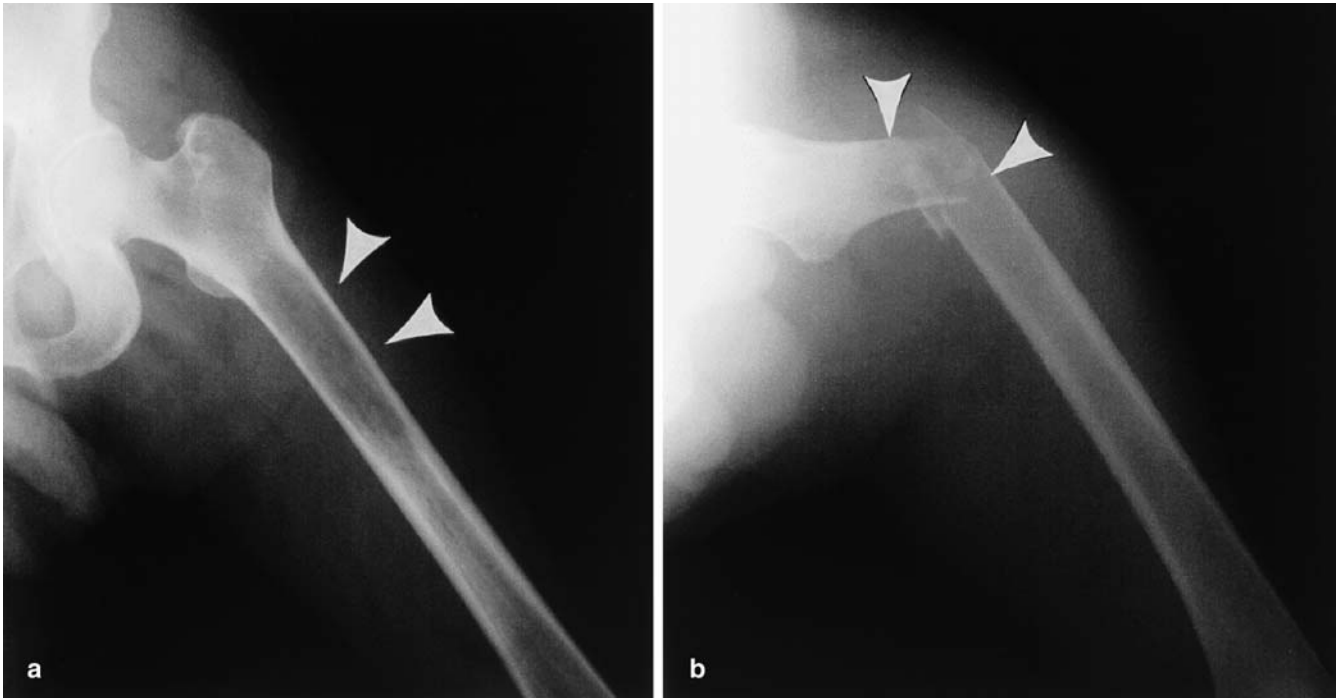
Extremity metastasis. a Radiography of the femur shows an osteolytic lesion in the left femoral shaft. b Pathologic fracture occurred 3 months later (*arrowheads*)
